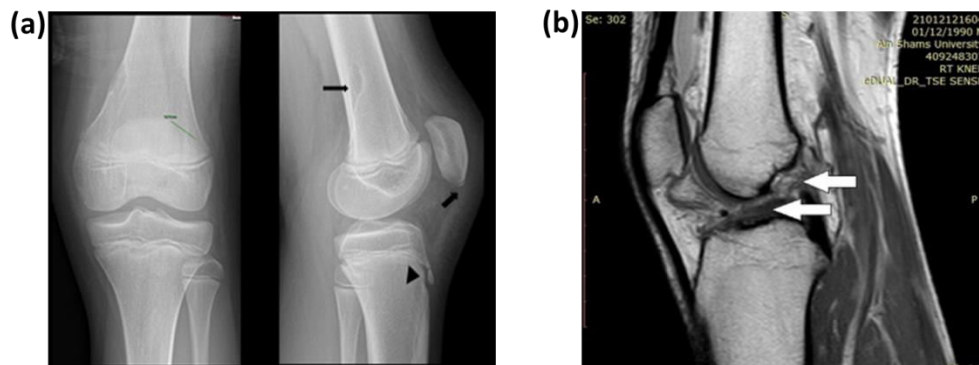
(a) Conventional X-ray of a subject with knee pain due to a fall 10 days before the examination and (b) MR image depicting the ACL tear.
